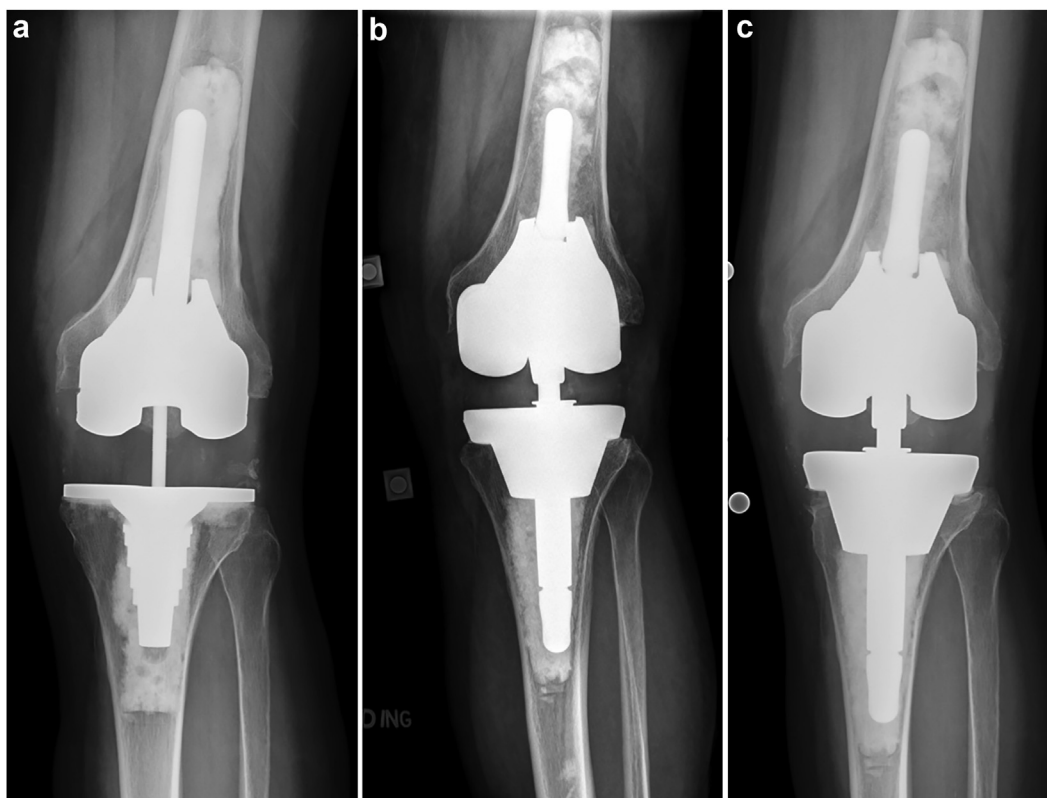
(a) Preoperative AP radiograph; (b) 6-week postoperative AP radiograph; and (c) a 5-year postoperative radiograph of a patient who underwent re-revision TKA for instability. The femoral cone was well-fixed and retained during the procedure. Diaphyseal impaction grafting was performed to cement femoral fixation within the diaphysis in the setting of a previously instrumented canal.
